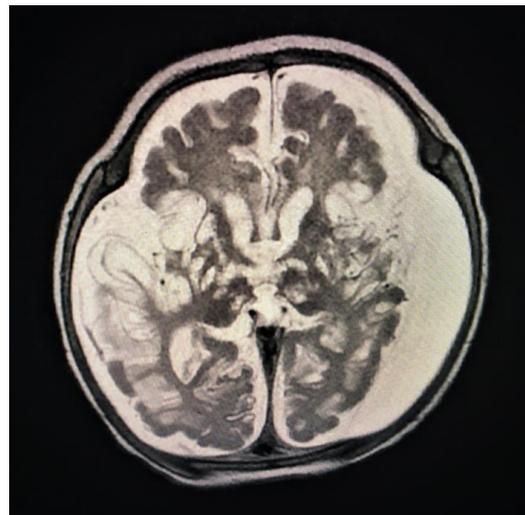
Diffuse atrophy and cystic dilatations in both hemispheres and effusion in both subdural distances on the second MRI
